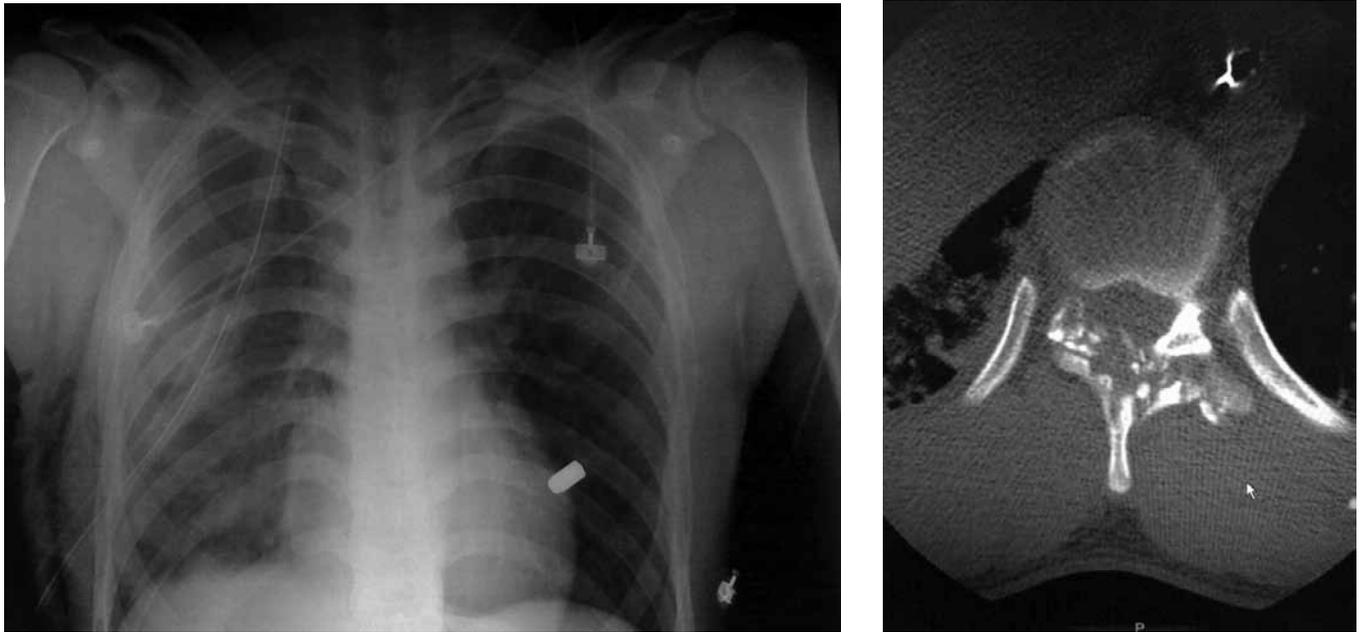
The majority of gunshot wounds to the spine are mechanically stable in patients with normal neurologic exams: (Left) This patient sustained a transthoracic gunshot wound. Right-sided hemothorax is noted and the missile is resting in the subcutaneous space of the posterior thorax. (Right) Mechanical stability was determined when CT images demonstrated isolated injury to the posterior column.*
